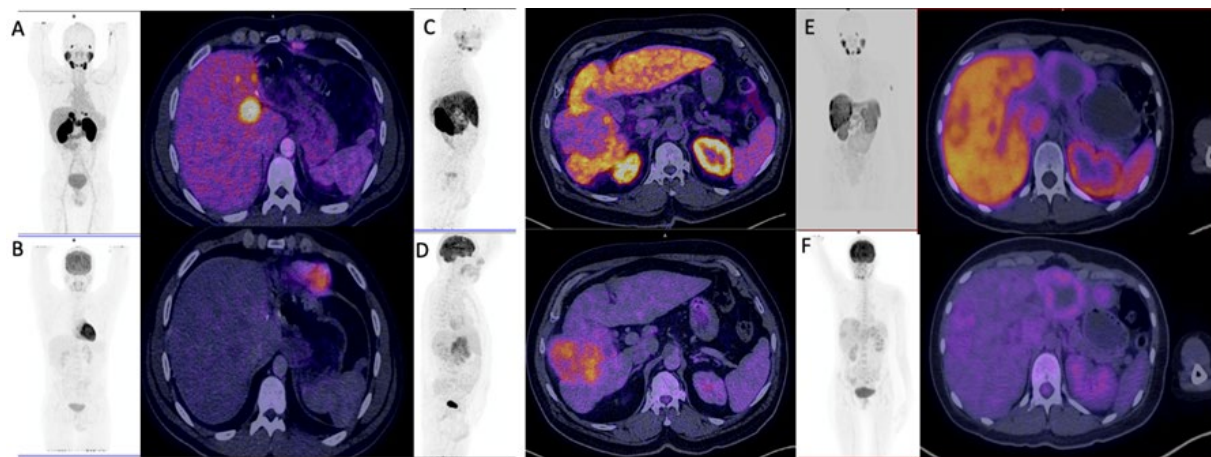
PET/CT ¹⁸F A) PSMA (+) B) FDG (-) C) PSMA (-) D) FDG (+) E) PSMA (+) F) FDG (-)
